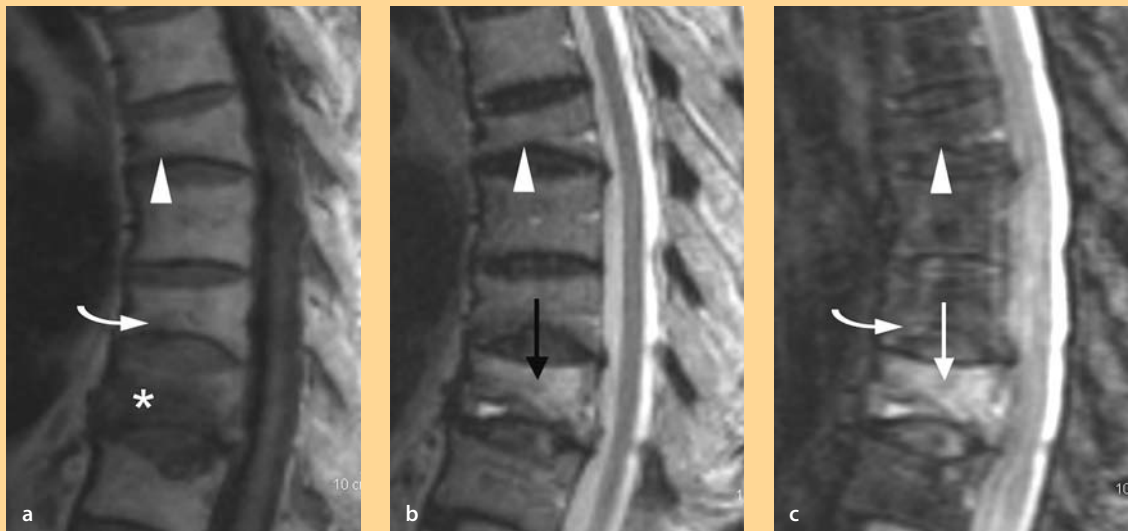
MRI in acute and old osteoporotic vertebral fractures
